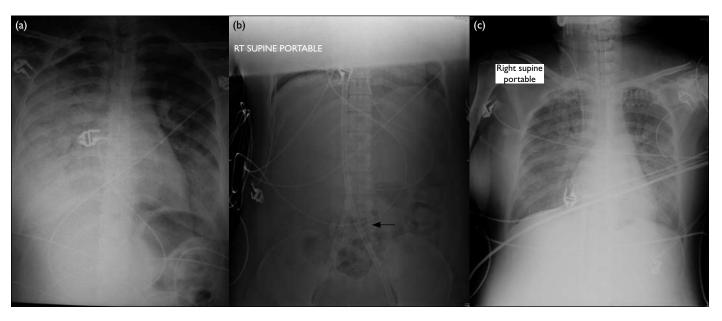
(a) Chest X-ray on admission; (b) abdominal X-ray after veno-venous extracorporeal membrane oxygenation catheters were inserted (arrow); (c) chest X-ray on day 10 of admission
